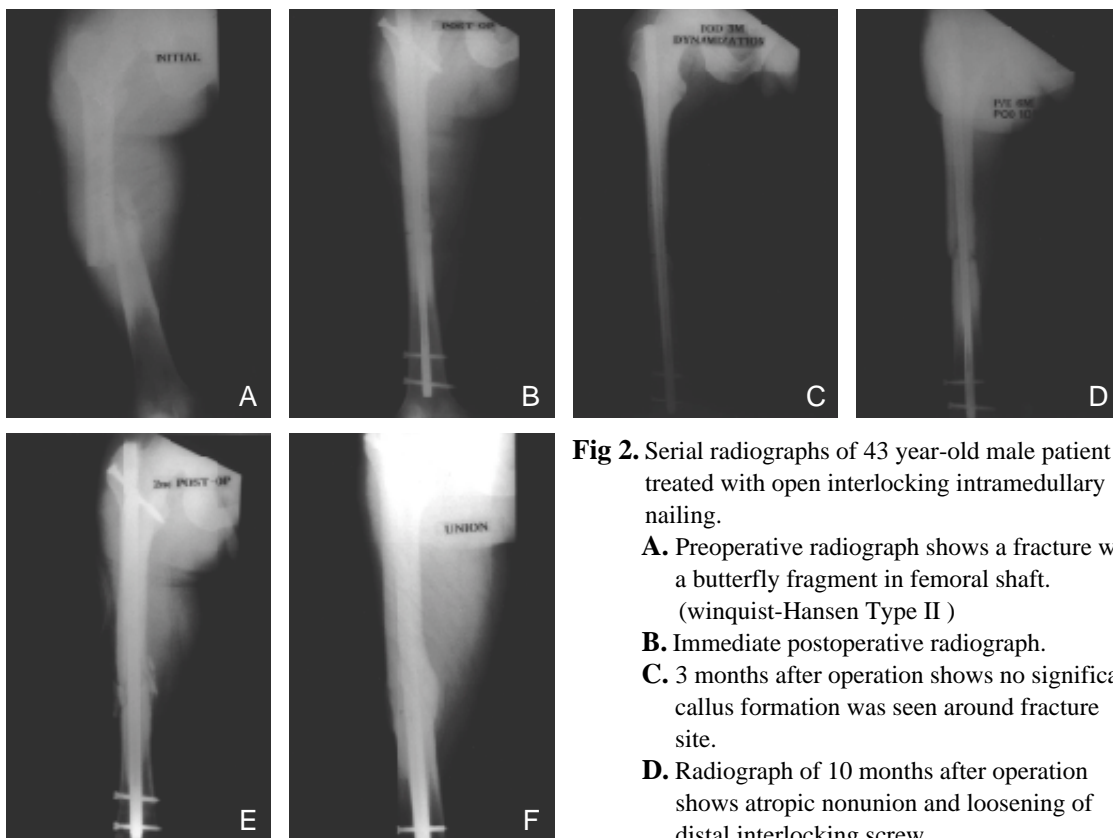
Serial radiographs of 43 year-old male patient treated with open interlocking intramedullary nailing.
